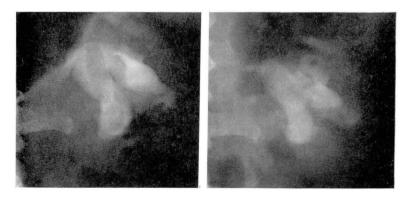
Roentgenograms showing that a large radiolucent defect of a uric acid stone (*left*) disappeared (*right*) after 15 months of allopurinol therapy and urinary alkalinization. (From O'Duffy, J. D., and Scherbel, A. L.: Allopurinol in the treatment of gout and urate calculi, Proceedings of the IV Panamerican Congress of Rheumatology, Mexico, *Excerpta Med. Found.*: in press; by permission of Excerpta Medica Foundation.)
